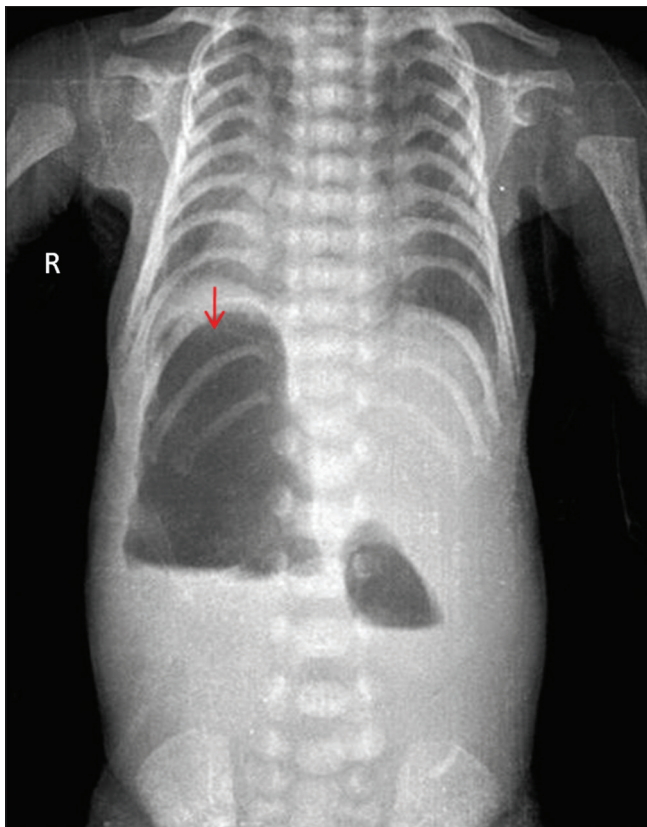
Thoraco-abdominal radiograph showing over-distended, right-sided stomach (red arrow) with narrow thoracic cage and short horizontally oriented ribs
